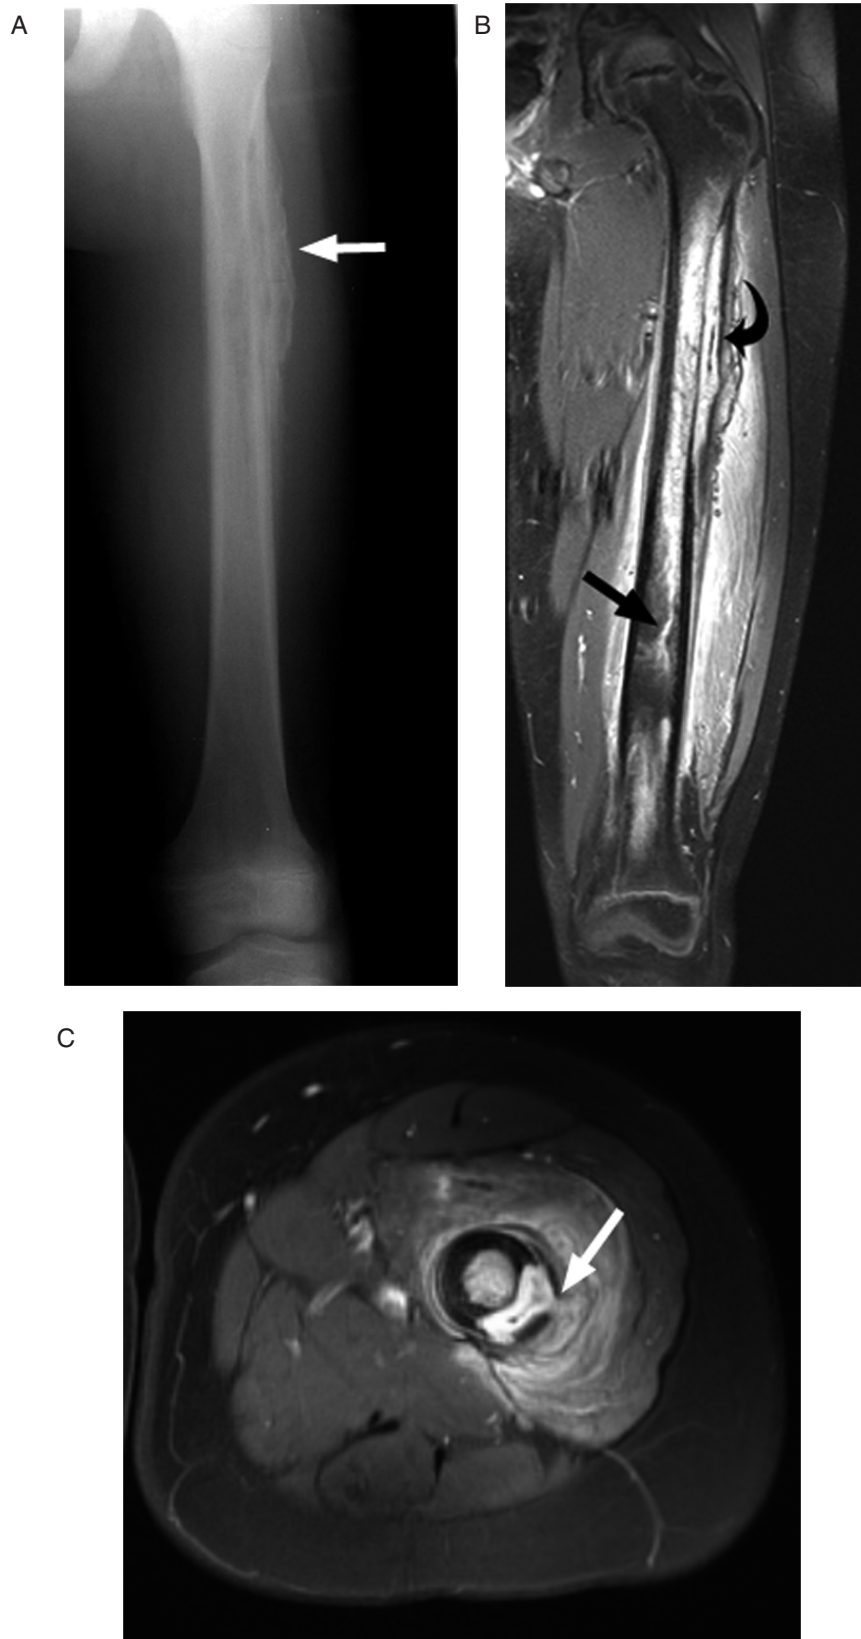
A 12-year-old boy with a 2-month history of limp and leg pain following minor trauma was found by biopsy to have chronic osteomyelitis. The patient was afebrile and had a normal white blood cell count but elevated C-reactive protein at the time of imaging. (A) This AP radiograph shows coarse, thickened periosteum (arrow). (B) This gadolinium-enhanced coronal MR image shows a subperiosteal abscess (curved arrow) and enhancing tract extending into the distal metadiaphysis. (C) This axial gadolinium-enhanced image shows a tract extending from the subperiosteal abscess into the abnormally enhancing surrounding muscle (arrow).
